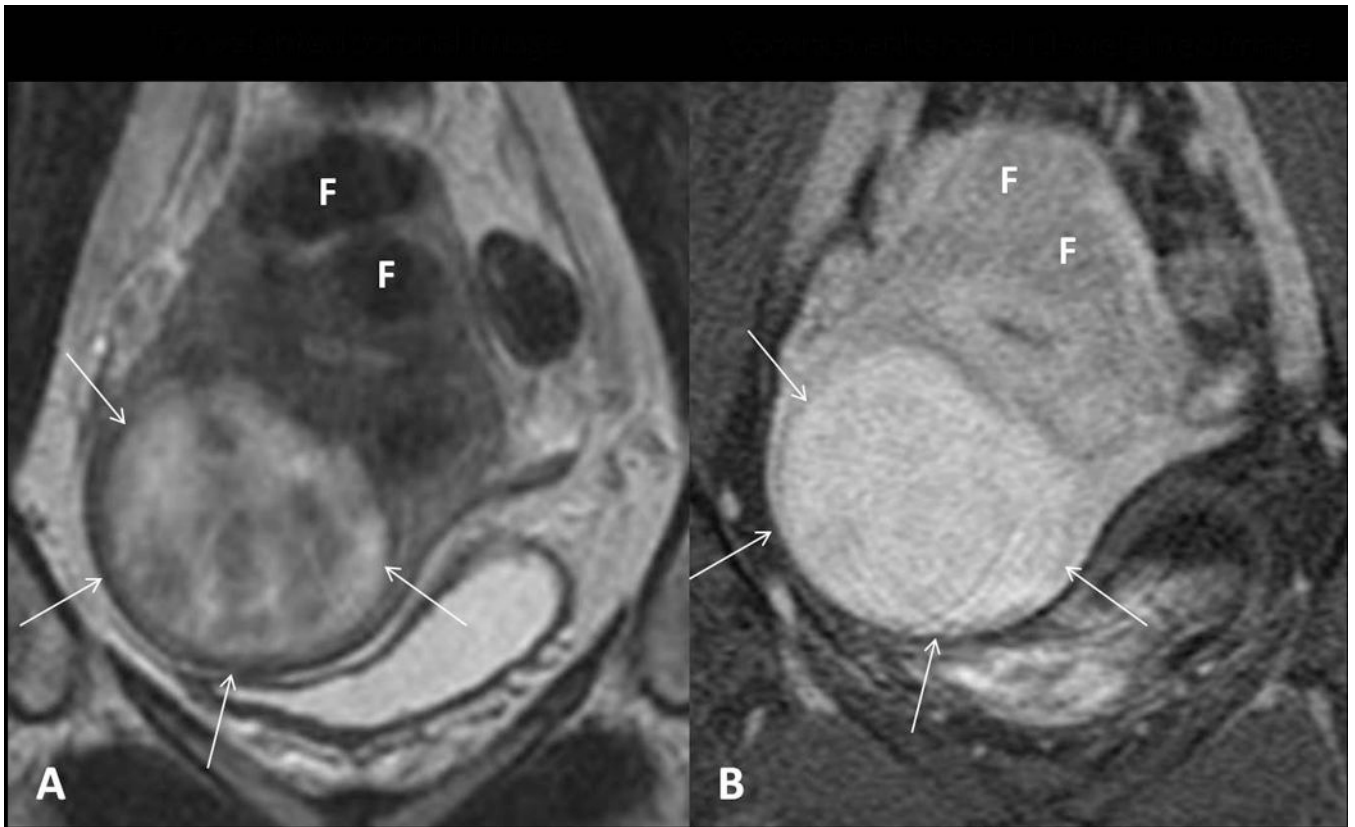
Hypercellular uterine fibroid. (A) On T2 weighted coronal MR imaging, the hypercellular fibroid (arrows) shows high signal intensity as compared to the other characteristic fibroids (F). (B) After IV Gadolinium contrast administration, it shows homogeneous enhancement.
